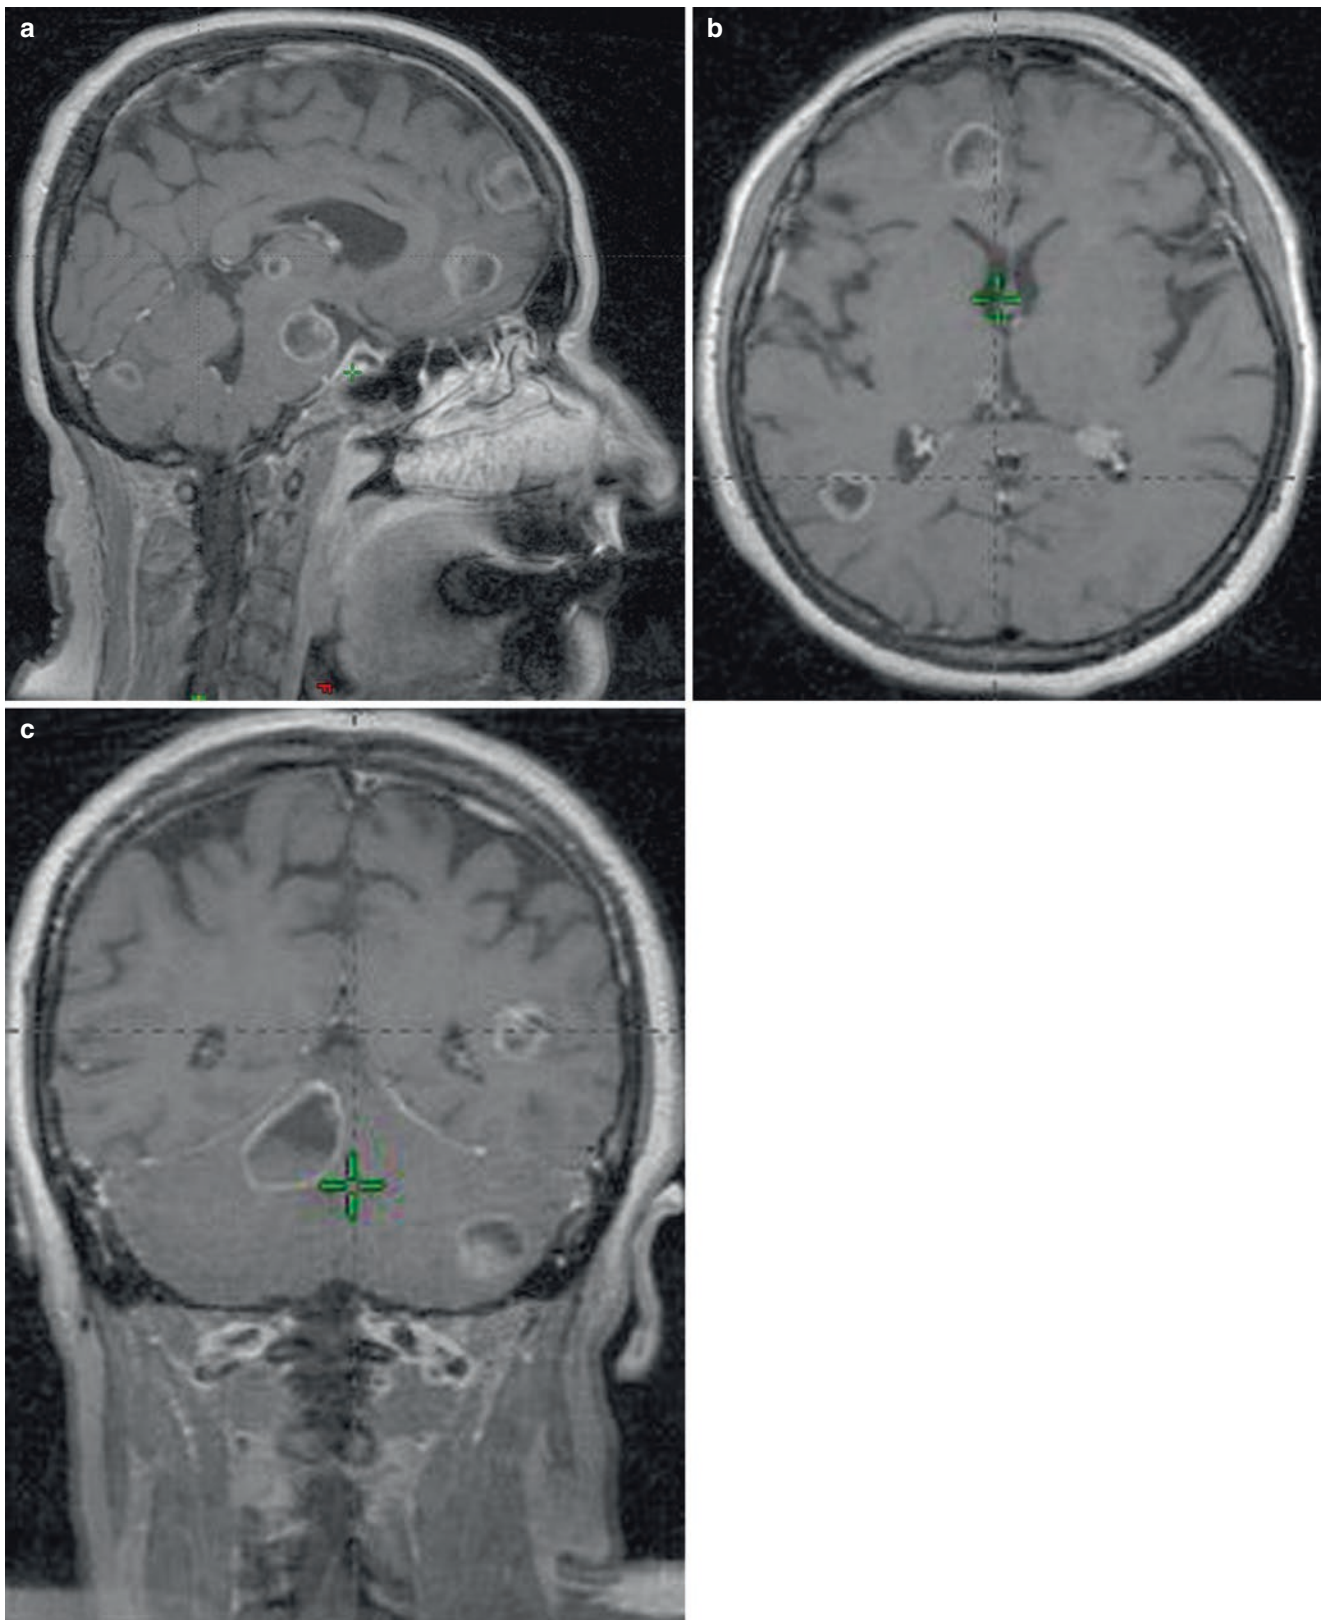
(a–c) MRI of multiple BMs in three planes
